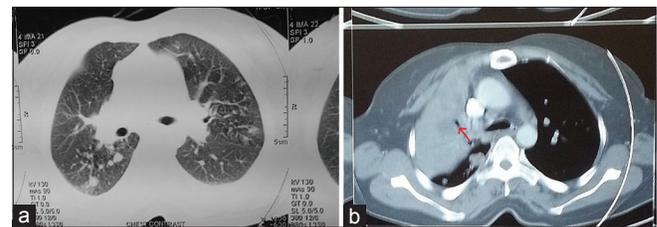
(a) CT showing 4-8-mm nodules suggestive of endobronchial spread in right UL (b) CT showing collapse of right UL with endobronchial obstruction. Bronchial cut-off sign noted in right UL
